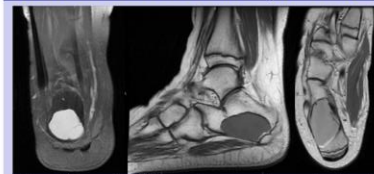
Pre-operative MRI revealed a unicameral bone cyst involving the calcaneus without fracture or other pathology.
